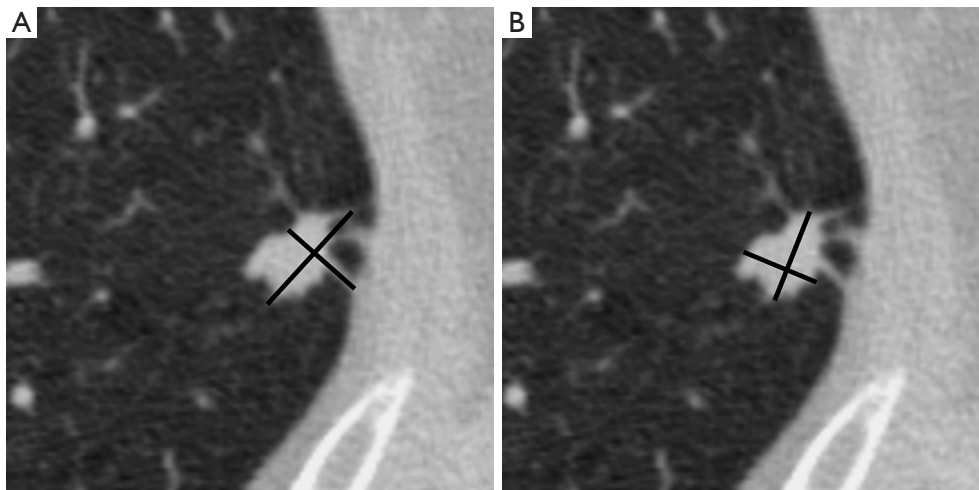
Axial CT images of a spiculated lung nodule. (A) The incorrect method is measured maximal diameter that included spiculation (cross line) causing overestimation of nodule size. (B) The recommended approach is to measure only the solid core (cross line). CT, computed tomography.
